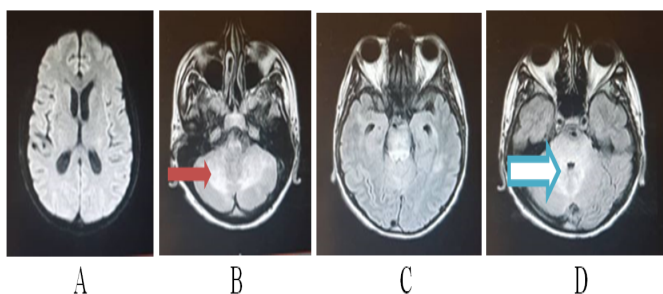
Braindiffusion MRI (A) showed no visible lesions, in MRI Flair sequence diffuseedema lesions of the cerebellar posterior fossa (B), brainstem and vermis (Cand D).
